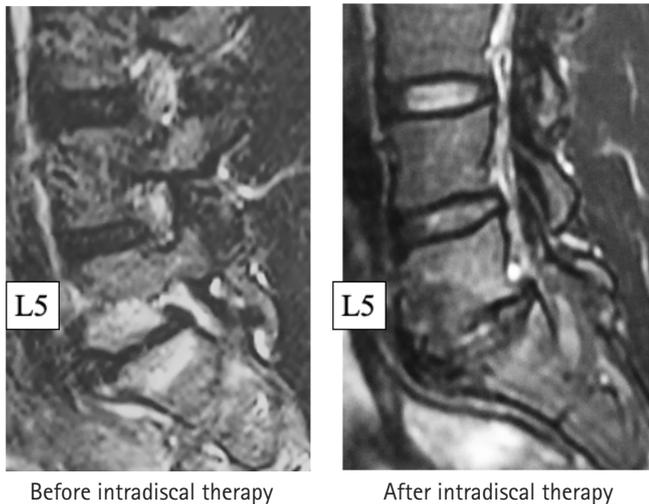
Short tau inversion recovery magnetic resonance images obtained before and after treatment for Modic change in a male martial arts fighter, who was a former world champion. Type 1 inflammation was clearly present before treatment but subsided following a couple of intradiscal injections. After intradiscal treatment, the Modic type was downgraded to type 3 sclerotic change.
